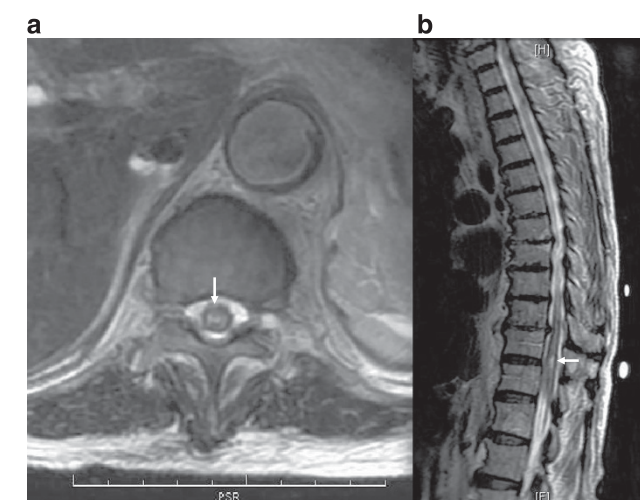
Axial (a) and sagittal (b) T2-weighted spinal MRI, showing central hyperintense lesion in the spinal cord at T11 (arrows).
